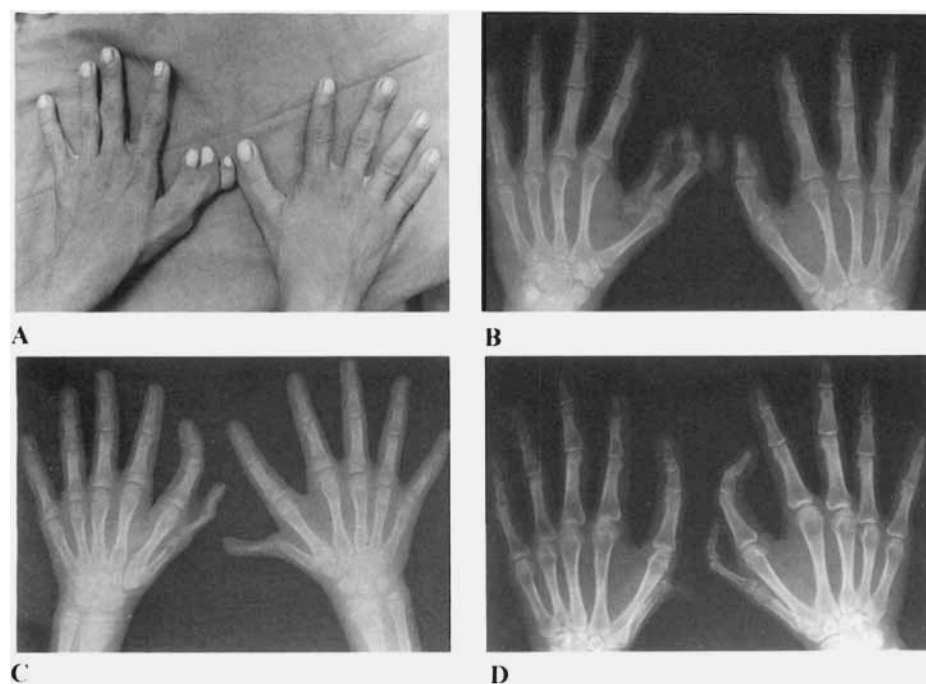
A: Clinical photographs and (B) radiographs of the same affected individual with triplication of left thumb and normal right hand. C-D: X-ray radiographs of 2 different individuals with bilateral triplication of the thumb and hypoplastic triplication of the thumb.
